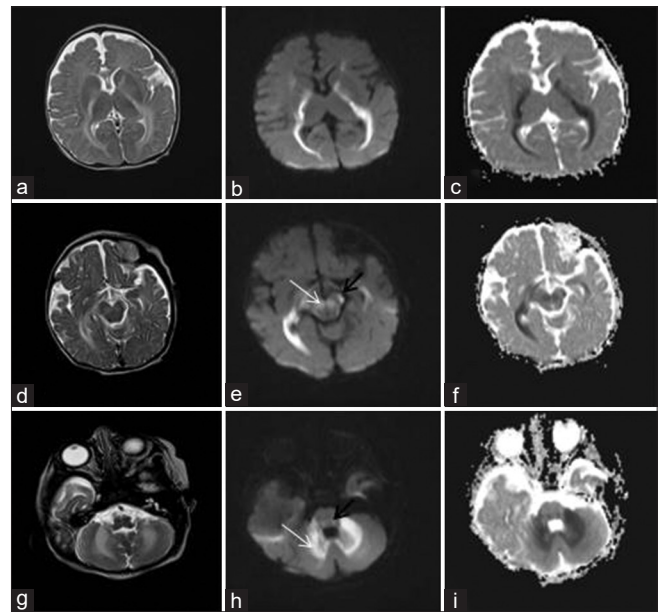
T2-weighted MRI images revealed hyperintensity in the posterior limb of internal capsule, optic radiation (a), cerebral peduncles, substantia nigra (d), and cerebellar white matter (g). Diffusion-weighted and ADC MRI images showed restricted diffusion in the posterior limb of internal capsule, optic radiation (b and c), cerebral peduncles (e and f; black arrow), substantia nigra (e; white arrow), the pyramidal tracts in the midbrain (h and i; black arrow), and cerebellar white matter (h and i; white arrow)
